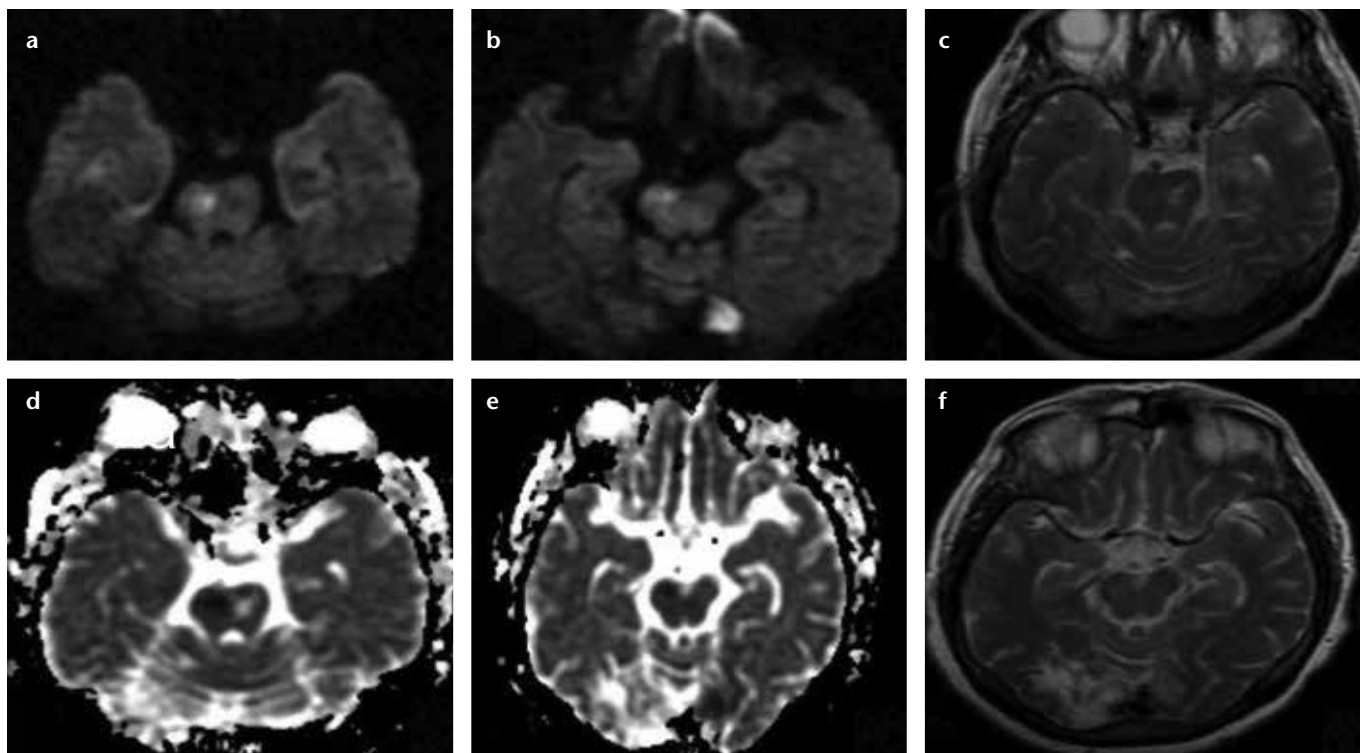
a–f. Axial diffusion weighted MR images (a, b) and apparent diffusion coefficient maps (d, e) show acute right-sided pontine and mesencephalon and left-sided occipital infarcts. Axial T2-weighted MR images (c, f) show left-sided pontine and right-sided occipital chronic infarcts.
